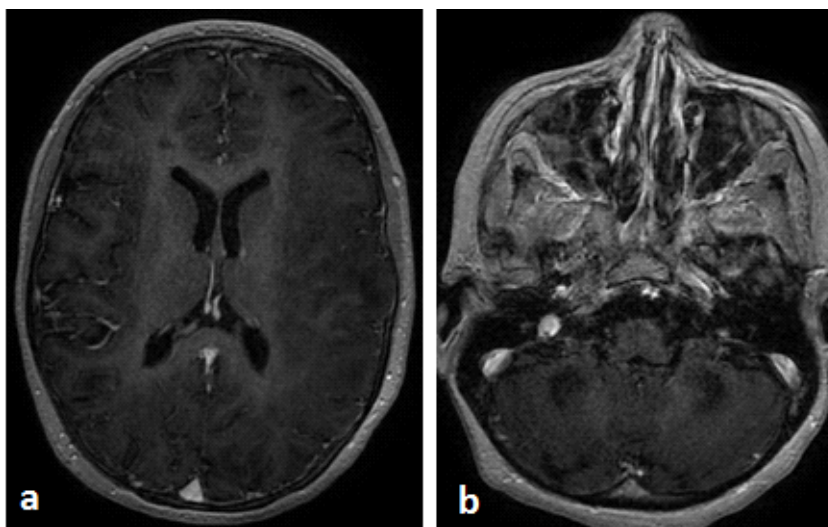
T1-weighted image in axial section after Gadolinium showing absence of pathological contrast enhancement in brain (a) and cerebellum (b)
